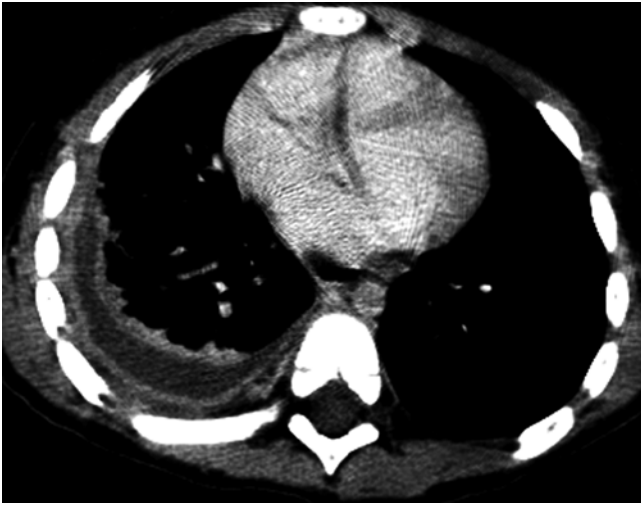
Parapneumonic fluid collection on CT scan. Image demonstrates right-sided pleural fluid with thick enhancement of both visceral and parietal pleura
